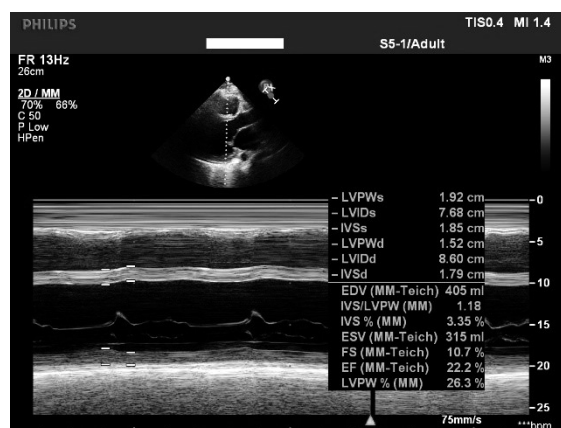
Echocardiogram on admission. LVPWs — posterior wall thickness end systole; LVIDs — left ventricular internal diameter end systole; IVSs — interventricular septal wall thickness end systole; LVPWd — posterior wall thickness end diastole; LVIDd — left ventricular internal diameter end diastole; IVSd — interventricular septal wall thickness end diastole; EDV — LV end-diastolic volume; ESV — end-systolic volume; FS — fractional shortening; EF — ejection fraction
